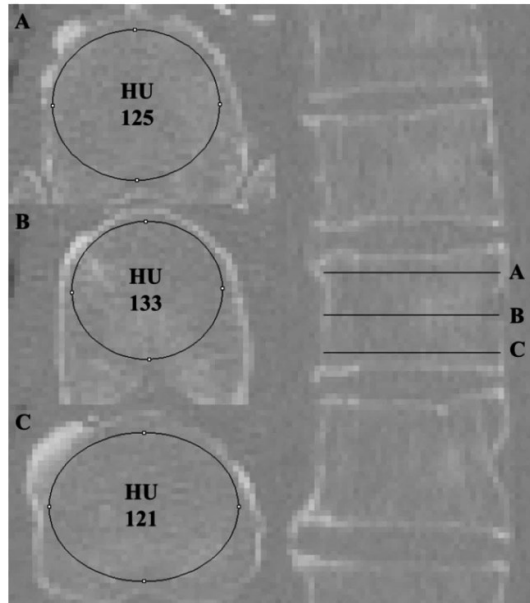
CT slice depiction of the elliptical regions utilized to characterize the bone density for each vertebral body.
